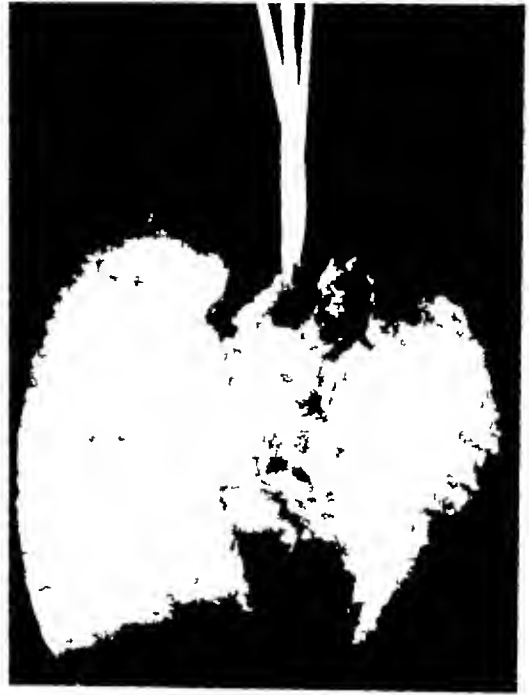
Case 3746 Roentgenogram of lungs following autopsy Lung mapping was attempted but was unsatisfactory Synopsis of autopsy findings reported in text
